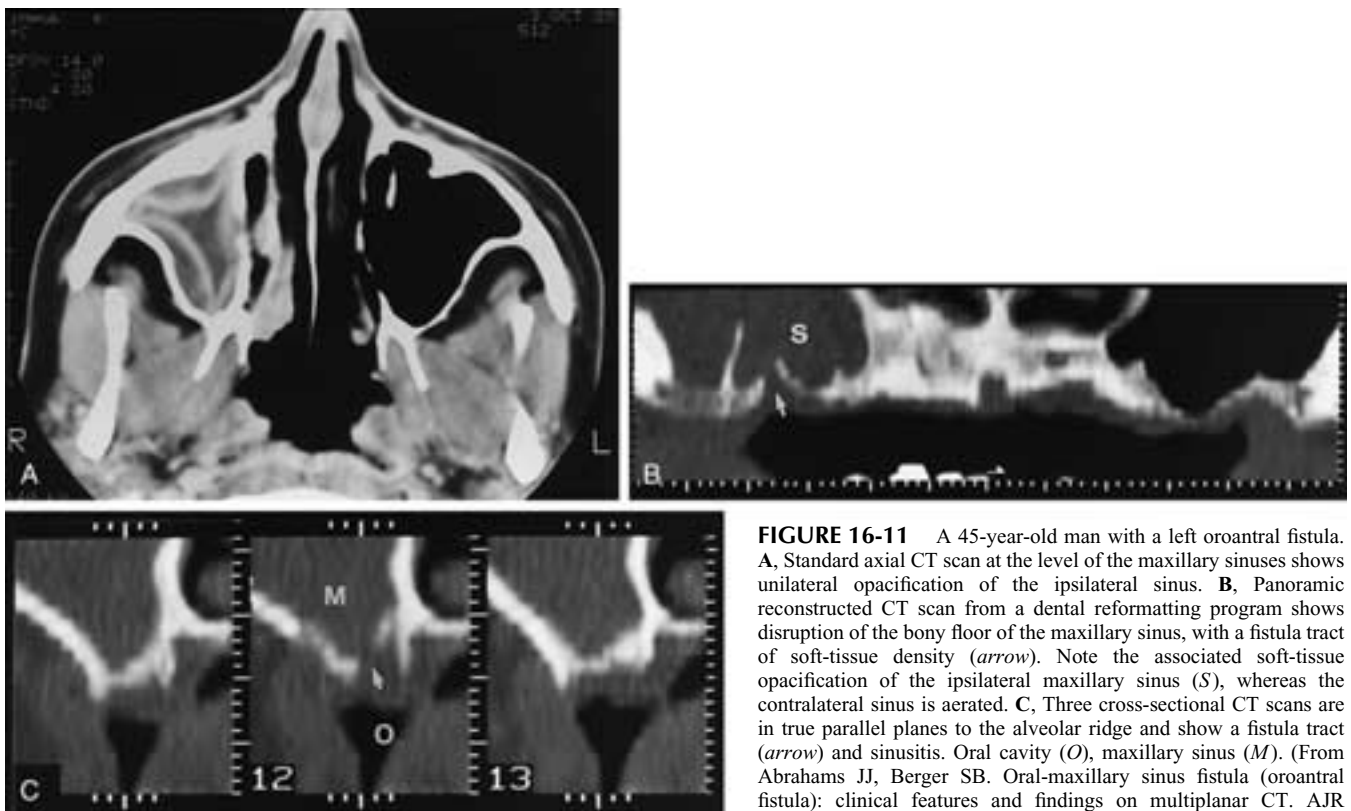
A 45-year-old man with a left oronasal fistula. A, Standard axial CT scan at the level of the maxillary sinuses shows unilateral opacification of the ipsilateral sinus. B, Panoramic reconstructed CT scan from a dental reformatting program shows disruption of the bony floor of the maxillary sinus, with a fistula tract of soft-tissue density (*arrow*). Note the associated soft-tissue opacification of the ipsilateral maxillary sinus (S), whereas the contralateral sinus is aerated. C, Three cross-sectional CT scans are in true parallel planes to the alveolar ridge and show a fistula tract (*arrow*) and sinusitis. Oral cavity (O), maxillary sinus (M). (From Abrahams JJ, Berger SB. Oral-maxillary sinus fistula (oronasal fistula): clinical features and findings on multiplanar CT. *AJR* 1995;165:1273–1276.)
